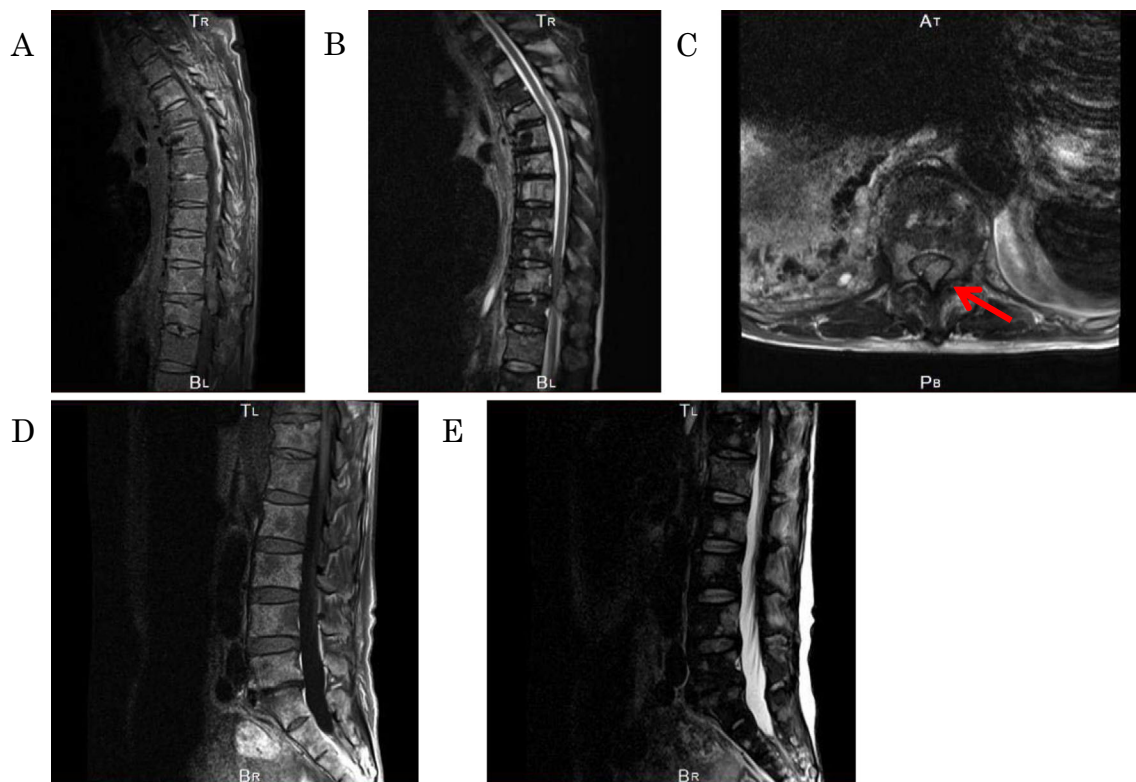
Spine MRI. Multiple bone metastases were of low intensity on T1-weighted imaging (A and D) and were of high intensity on fat suppressed imaging (B and E). A vertebral metastasis in Th11/Th12 showed spinal cord compression on axial T2-weighted imaging (C).
